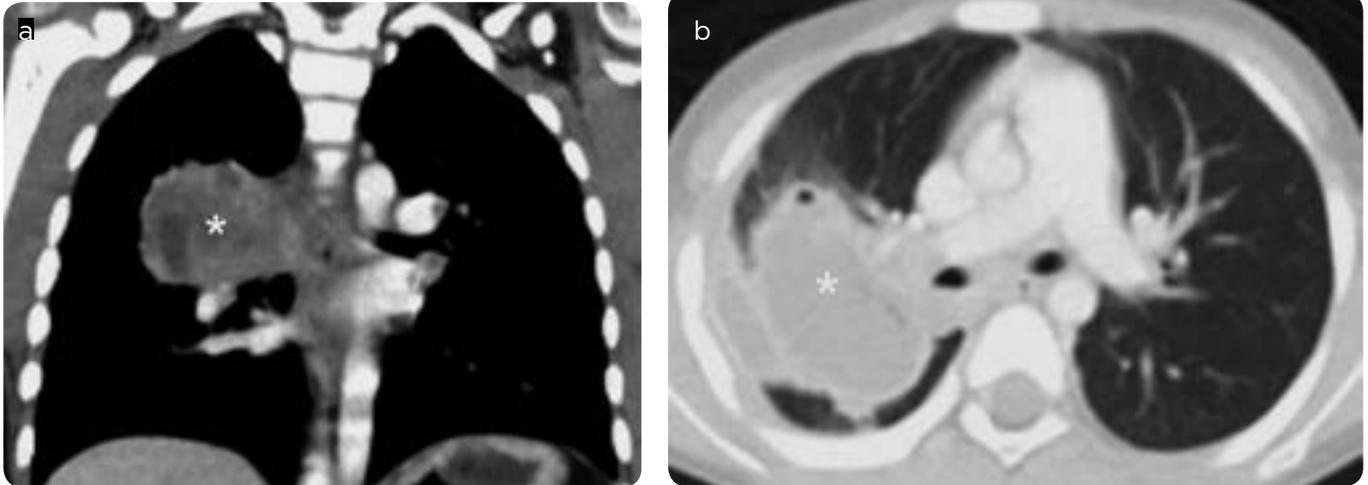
Pleuropulmonary blastoma. 3-year-old girl. a and b) CT scan of chest, coronal, mediastinal and pulmonary window. Solid-looking mass, lobed contours and heterogeneous density in the posterior segment of the right upper lobe.
